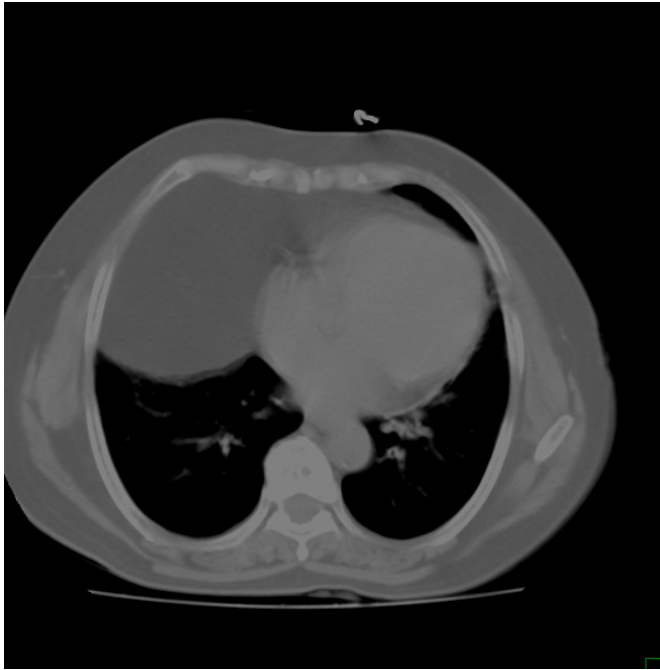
CT showed a smooth edged mass, with homogenous hypodensity measuring 9.8 x 11.2cm in size with radiological findings of fat (-50 to -100 Hounsfield units).
